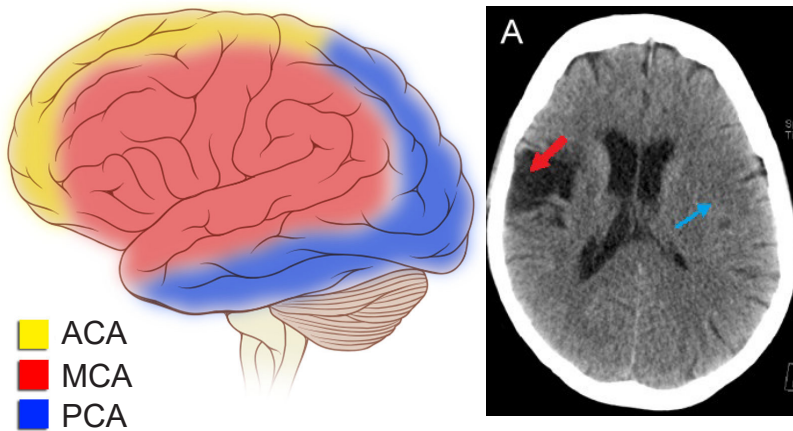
Areas of the cortex that receive blood flow from specific arteries (left). The middle cerebral artery (MCA) provides perfusion to frontal, parietal, and temporal areas that are important for language. CT scan of a patient after a stroke of the MCA, showing loss of brain tissue (red arrow, right).
